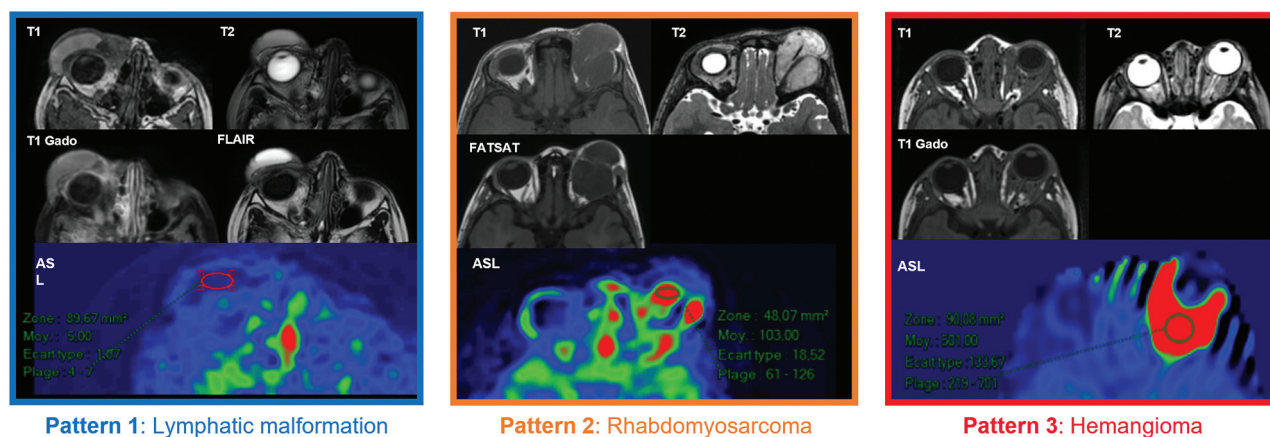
Conventional MR imaging sequences and ASL maps of representative patients for the 3 perfusion patterns. Pattern 1 (homogeneous hypoperfusion profile, characterized by cold dark colors on the CBF map over the lesion area): Lymphatic malformation, right vascular anomaly (patient 12, mean LBF = 10 mL/min/100g tissue, rLBF = 0.24). Pattern 2 (heterogeneous hyperperfusion profile, consisting of multiple bright color patches within the lesion area): Rhabdomyosarcoma, left malignant tumor (patient 24, mean LBF = 74 mL/min/100g tissue, rLBF = 1.84). Pattern 3 (homogeneous very intense hyperperfusion profile, corresponding to a uniform bright warm color area in the CBF maps): IH, left vascular anomaly (patient 16, mean LBF = 515 mL/min/100g tissue, rLBF = 18.73). Conventional sequences: T1 and T2 WI, T1 Gado (T1WI with gadolinium-based contrast medium), FLAIR, FATSAT (fat-suppression T1WI sequence).
